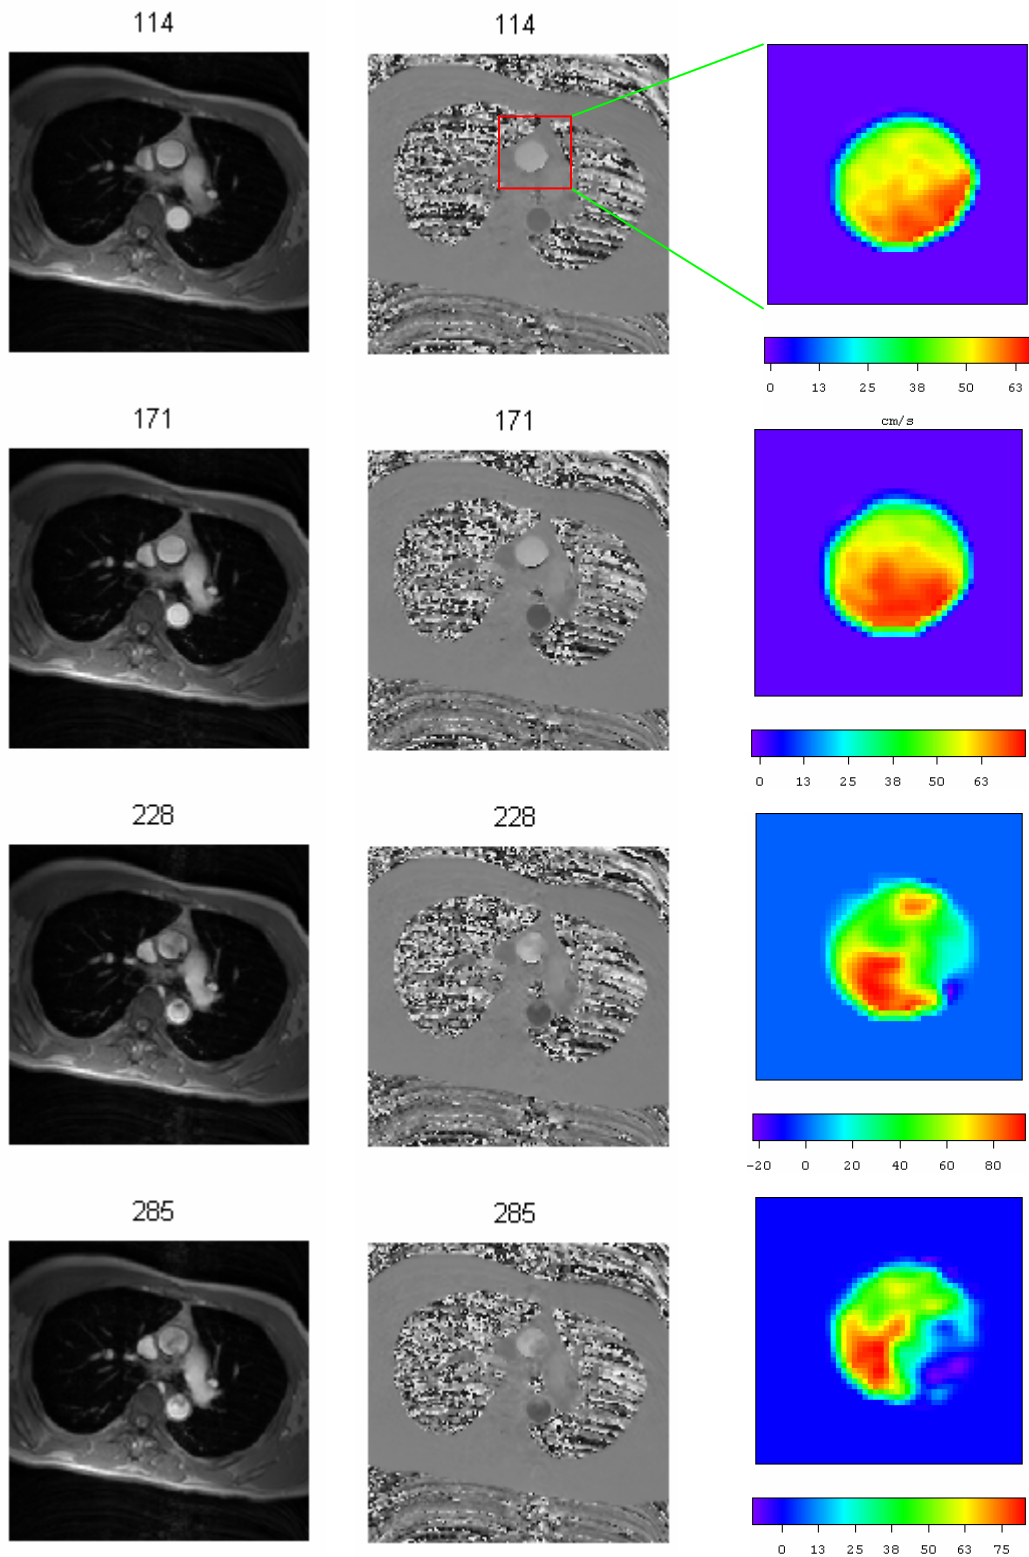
Eleven PC-MRI slices in the middle section of ascending aorta across 114 - 683 milliseconds (see the red line in the Time axis of Figure 3.22): the lefts are the modulus images; the middles are the phase images; the rights are the axial velocity distributions in the lumens of the ascending aorta.
